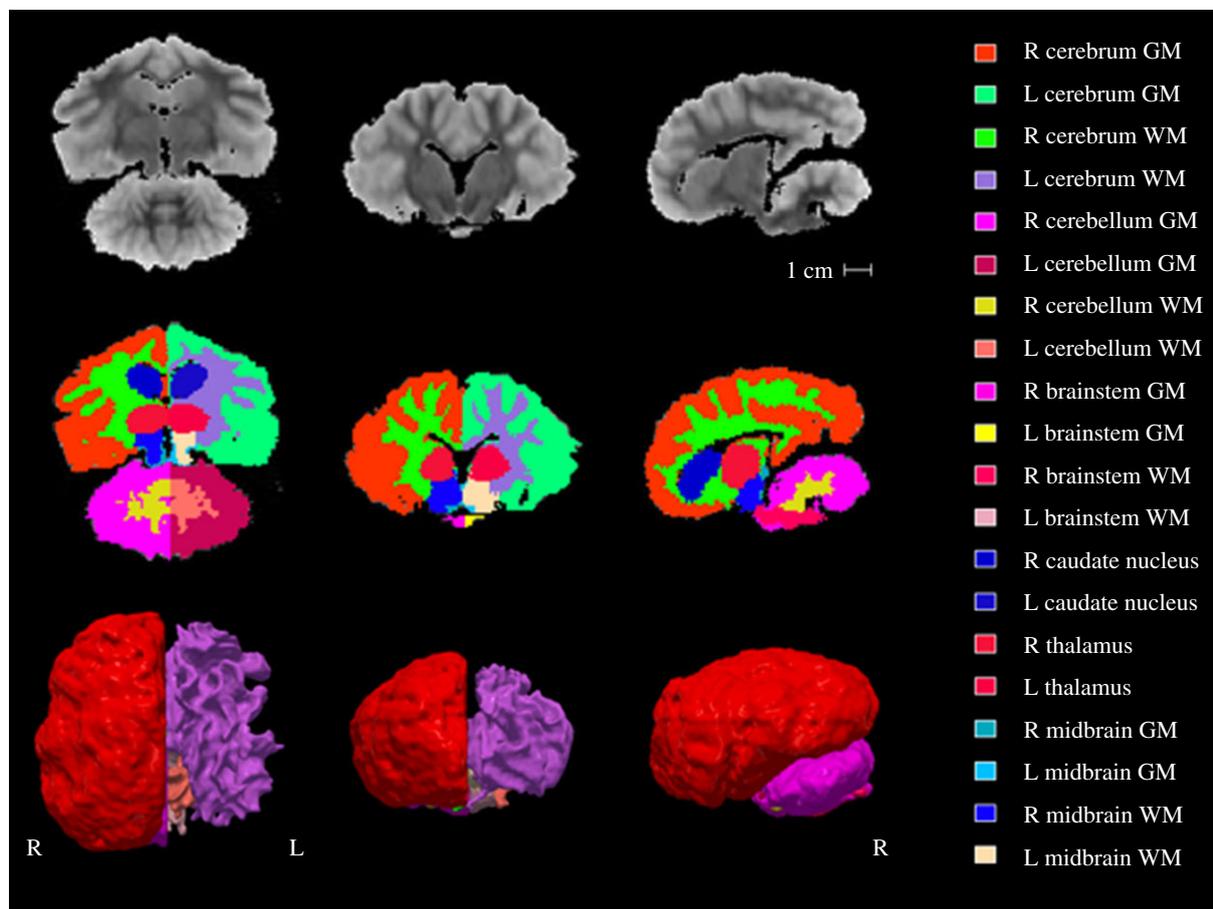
Overview of the grey seal brain template created from Grey Seal Brain 2. From left to right, the transverse (rostral portion on top), coronal and sagittal (rostral portion on the left) views are shown in radiological convention (right hemisphere on the left side). Top row: T2 FLAIR brain template. Middle row: segmented and labelled brain template. Bottom row: three-dimensional reconstruction of the brain surface from the dorsal (left), frontal (middle) and lateral (right) view showing the grey matter outer boundary on the right hemisphere and the white matter surface on the left. Abbreviations: L, left; R, right; WM, white matter; GM, grey matter.
